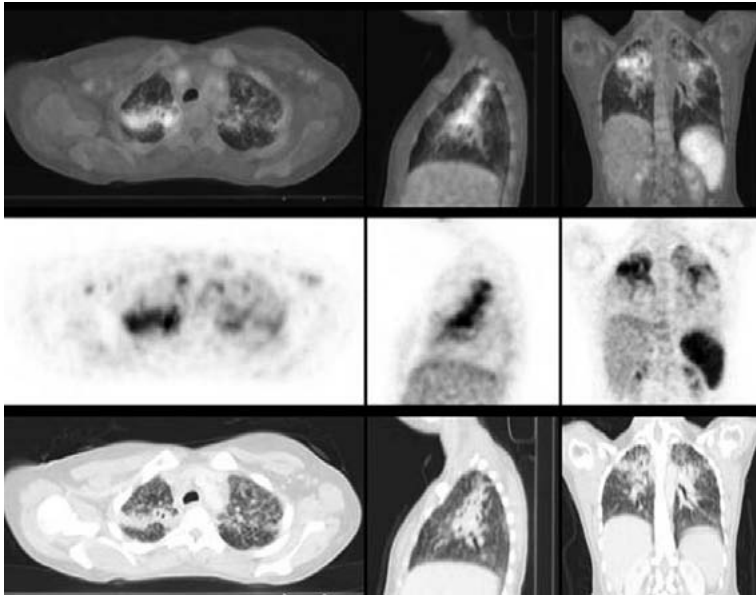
Sarcoidosis patient with signs of pulmonary fibrosis and ^{18}F -FDG PET activity.
